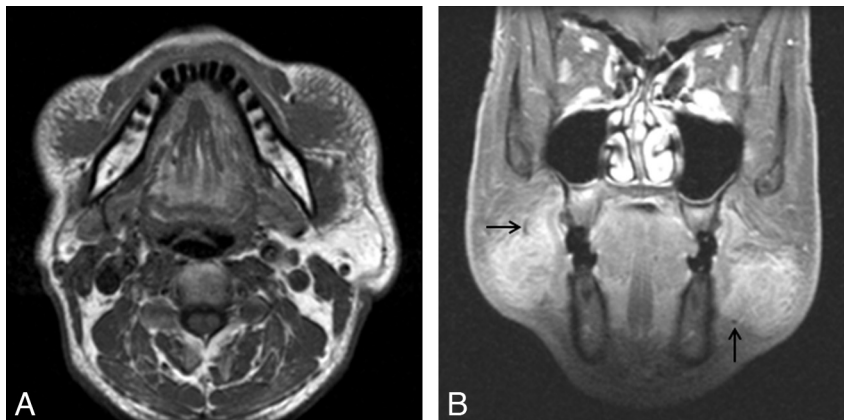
KD involving bilateral buccal spaces in a 52-year-old man. *A*, Axial T1-weighted MR image demonstrates ill-defined soft-tissue masses in the bilateral buccal spaces, isointense to the adjacent muscle. Note the reticular infiltration of the subcutaneous tissue around the lesions. *B*, Postcontrast coronal fat-suppressed T1-weighted MR image demonstrates homogeneous marked enhancement of the lesions. Note tubular or dotlike signal-intensity voids at the periphery of the lesions, probably representing fast-flowing vascular structures (arrows).
